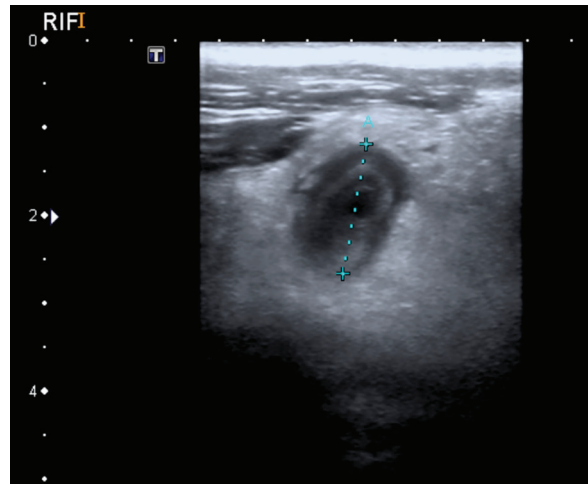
High resolution ultrasound demonstrating acute appendicitis; appendiceal dilatation, oedema of its wall resulting in the 'target sign' and adjacent fat stranding. Note the calipers (A) which indicate an appendiceal diameter of >6 mm.
